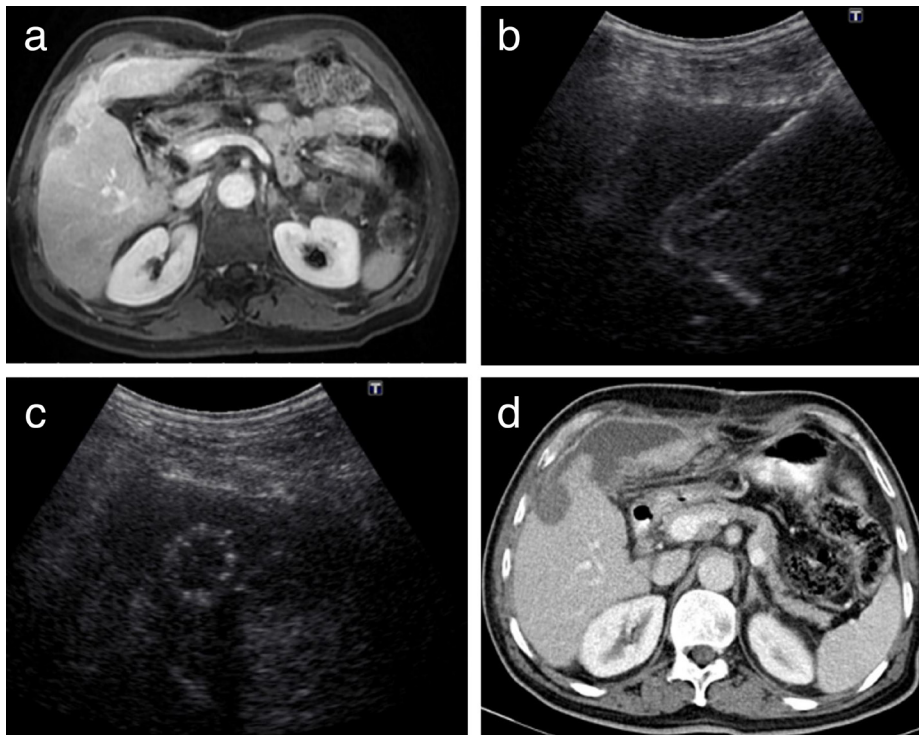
Abscess formation after MWA of CRC metastasis. A segment-5 metastasis is visible on the portal venous phase enhanced MRI (a). Ultrasound-guided intraoperative MWA and the ablation zone with echogenic borders are seen (b, c). On the fourth day after surgery, an abscess associated with the ablation zone and subcapsular suppuration were observed on contrast-enhanced abdominal CT examination (d), which was performed after the addition of fever to persistent right upper quadrant pain. CRC, colorectal carcinoma; MWA, microwave ablation; CT, computed tomography; MRI, magnetic resonance imaging.
